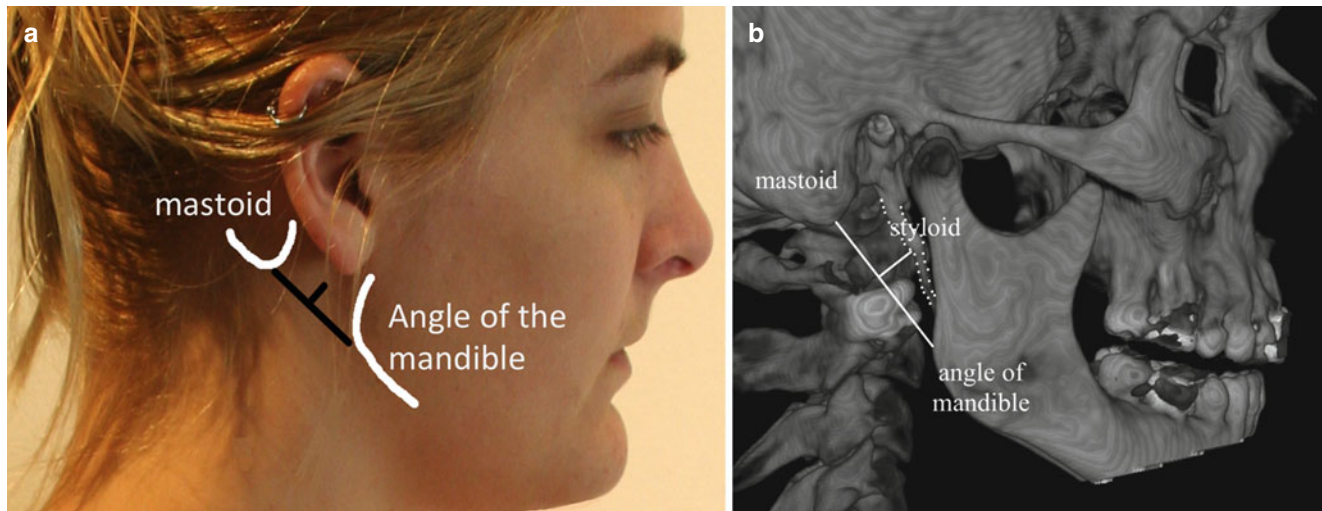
Surface anatomy (a) and 3D X-ray image (b) of the styloid process (*outlined*). Imaginary line is drawn from the mastoid to the angle of the mandible; styloid process will be found at the halfway point of this line (Image courtesy of Andrea Trescot, MD)
